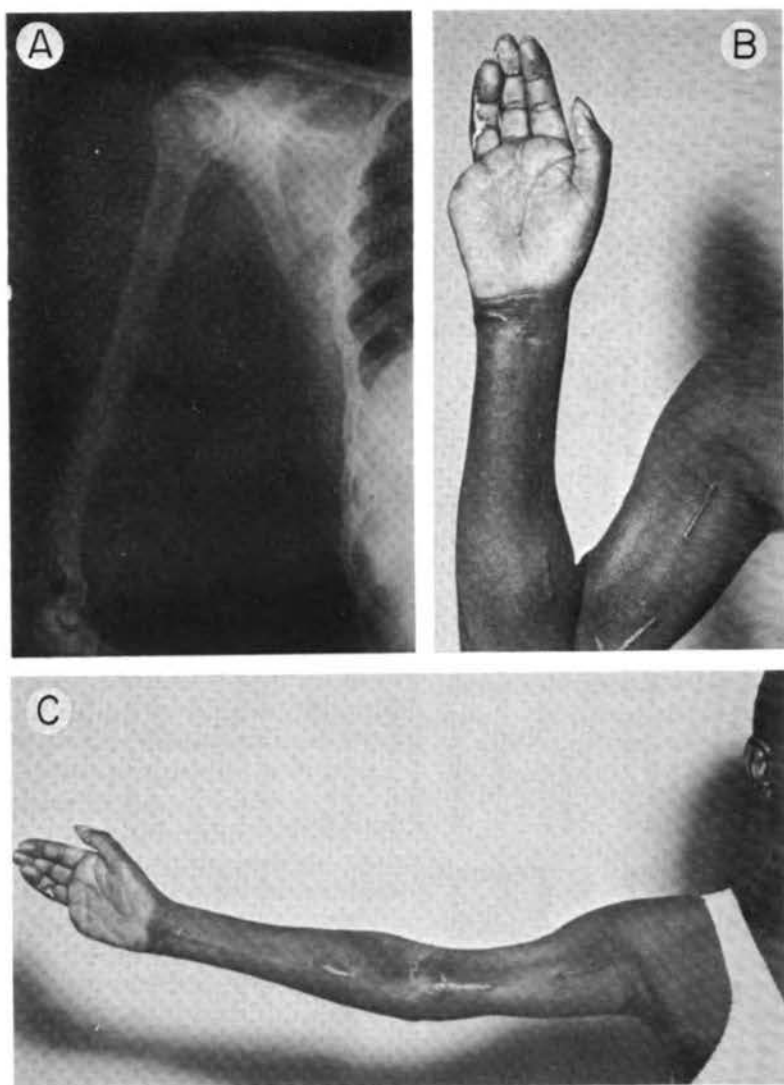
A, roentgenographic evidence of gas infiltration of shoulder region in a patient who, on his job as a watchman, was stabbed in the upper arm just above the elbow and subsequently developed clostridial infection in the wound site. B and C, healing of wound (ragged scar) after OHP therapy. (Other scars resulted from surgical incision.) The little finger had to be amputated because of necrosis, but the remainder of the hand and arm was saved. Recovery of function was delayed by concomitant nerve injury.
